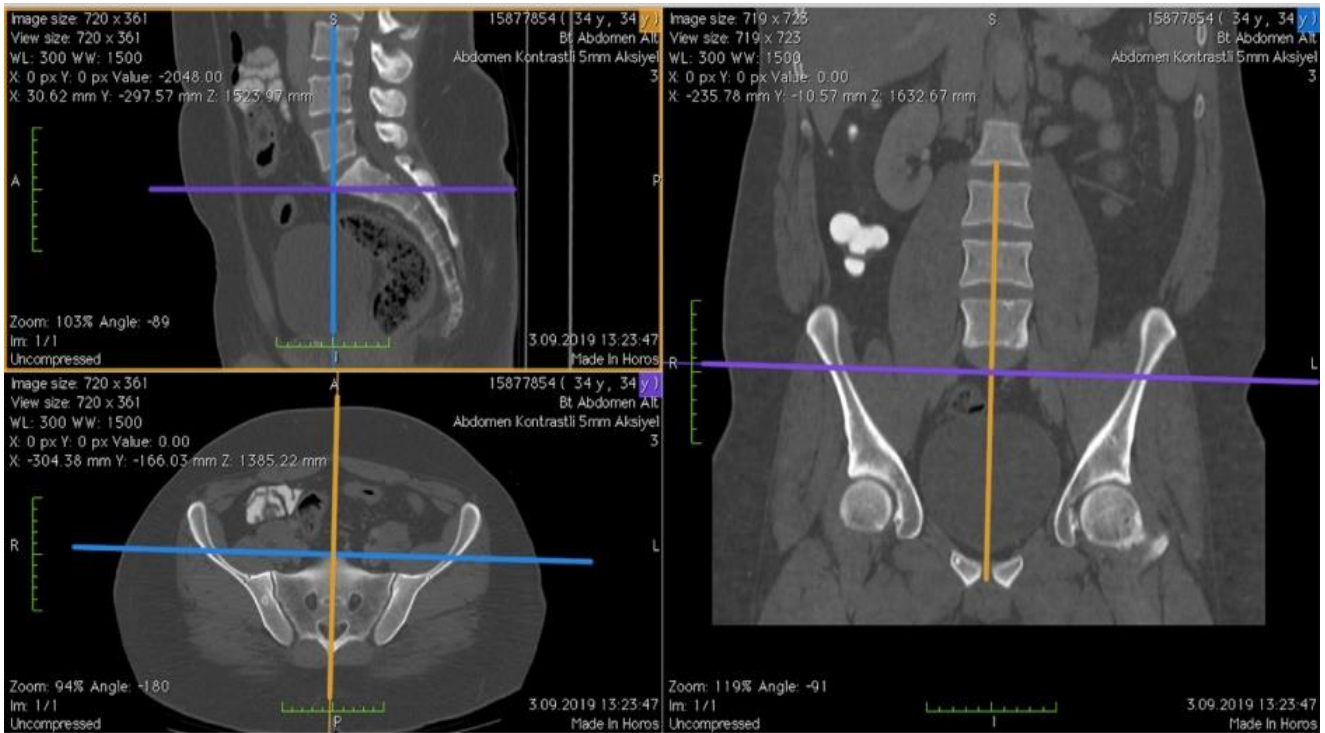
CT Images on the 3D Orthogonal Plane in Horos Software
